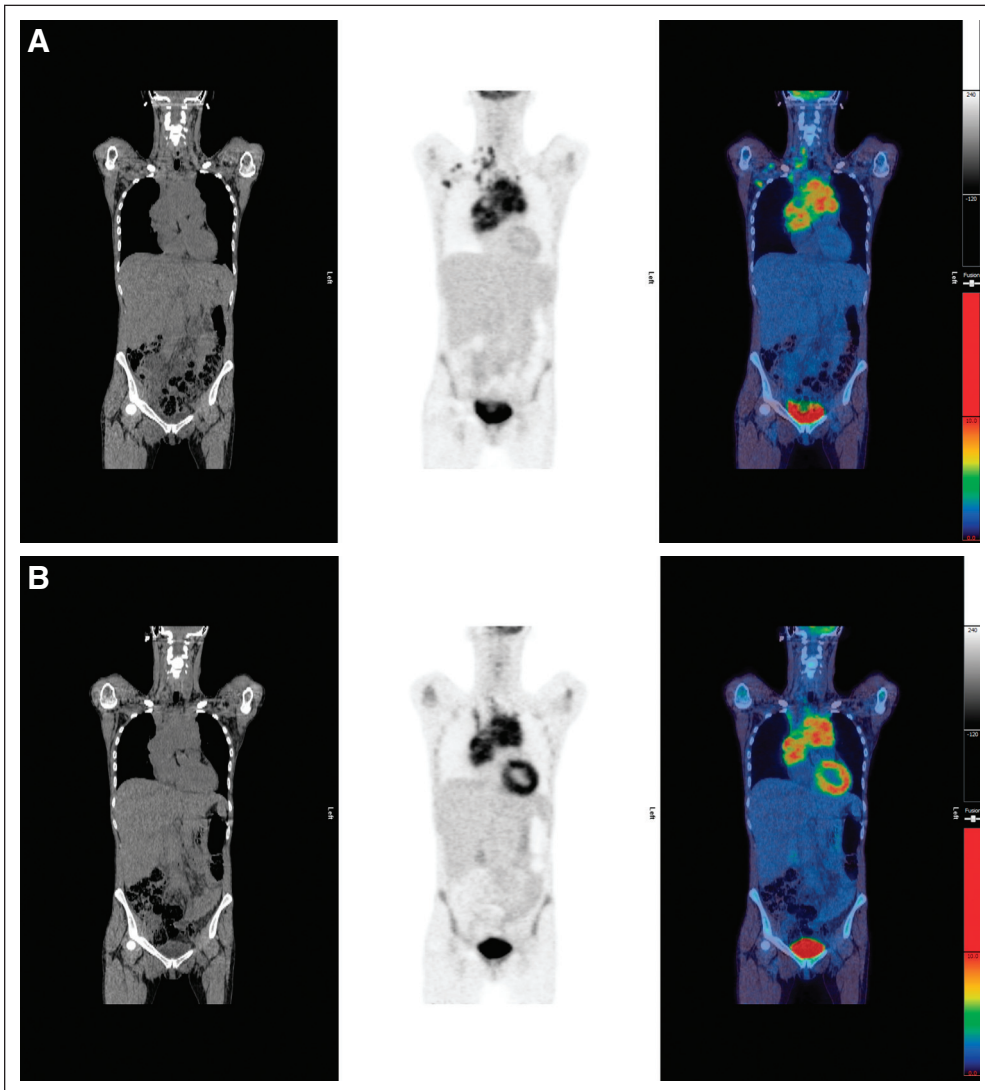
(A) Pretreatment scan: computed tomography, positron emission tomography, and fused images showing disease in right neck, mediastinum, and right axilla. (B) Example of score 5: residual uptake in mediastinum with intensity markedly higher than normal liver. Maximum standardized uptake value (SUVmax) in mass was 13.0; SUVmax in liver was 2.3.
